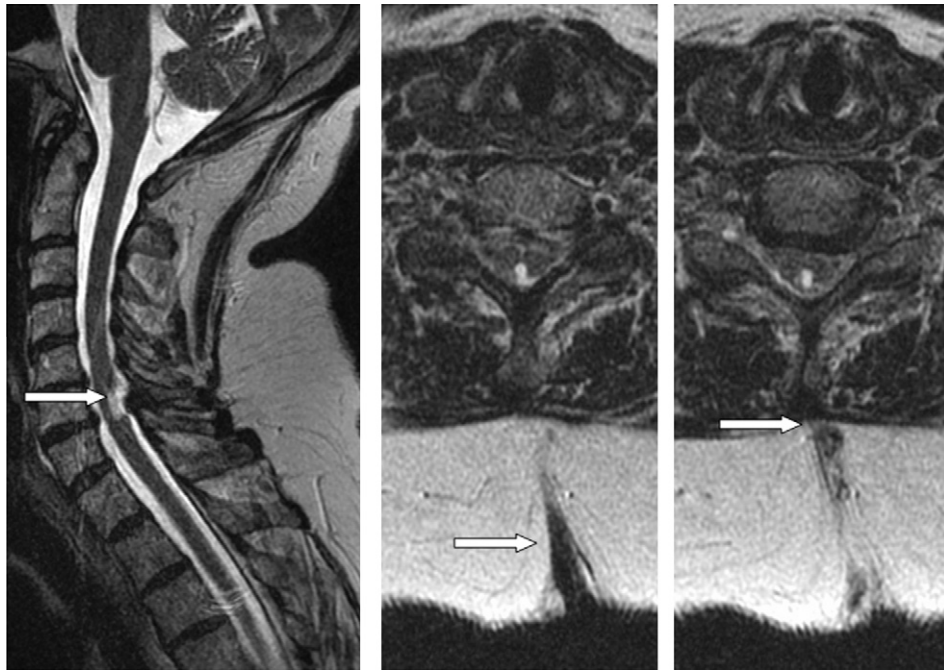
Sagittal (left) and axial (middle, right) T2-weighted MRI showing a dermal sinus tract (arrow – middle, arrow – right) associated with a signal hyperintensity (arrow – left) in the dorsal columns.
